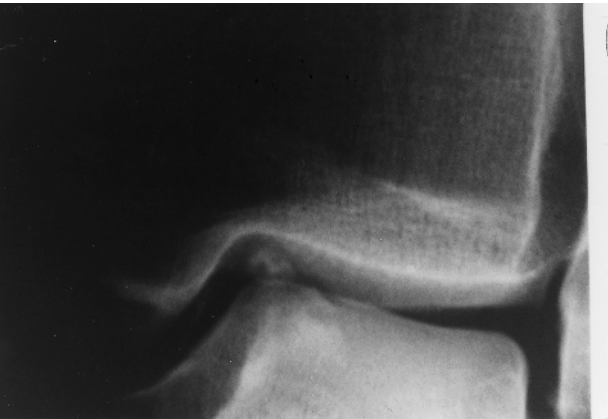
Radiograph of an entrapped loose body in the medial corner.
